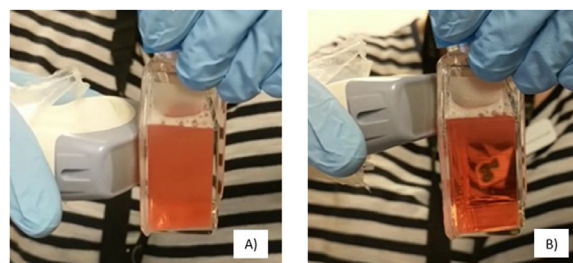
Images of the ultrasound exposure revealing how the transducer was moved across the surface of the flask for ~ 90 s until the milky white microbubbles as seen in (A) had burst and the medium returned to its normal transparency (B).
